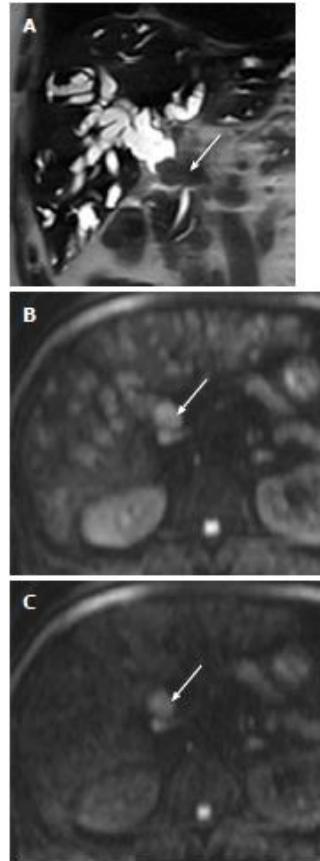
extrahepatic cholangiocarcinoma in a 62-year-old man. A: Coronal T2-weighted rapid acquisition relaxation enhancement image shows a mass (arrow) in the distal common bile duct and marked upstream bile duct dilatation; B: DWI at $b = 800$ s/mm² shows a mass with high signal intensity (arrow), but the signal intensity of bile is also increased; C: DWI at $b = 1000$ s/mm² shows a mass with high signal intensity (arrow). Note that the signal intensity of bile in the bile duct is significantly reduced. DWI: Diffusion-weighted magnetic resonance imaging. Thus, this finding can be a clue for differentiating between malignant and benign biliary lesions. However, there is some degree of overlap; benign active inflammatory conditions rarely have hyperintensity, and some
